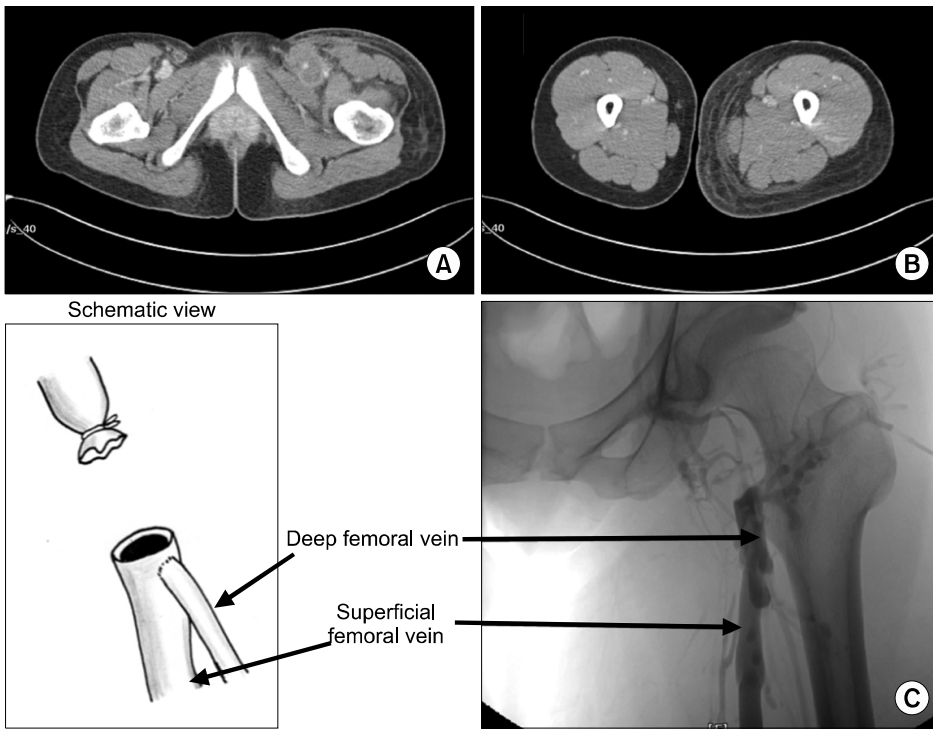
Computed tomographic scan and venographic images. (A, B) The left femoral vein above the proximal superficial femoral vein was not visualized by computed tomography. (C) Venography showed that the left femoral vein had been divided and that thrombosis was present around its stump.
